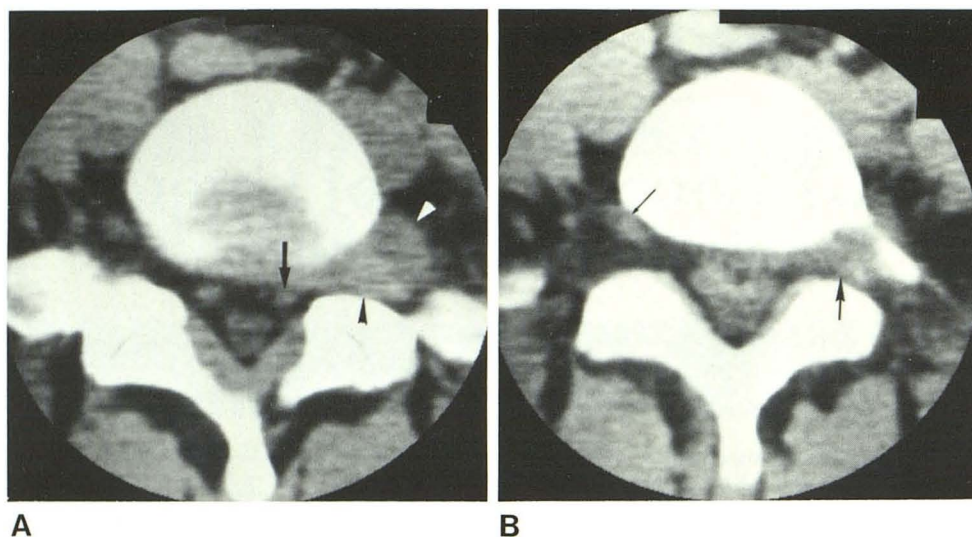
Case 1. Lateral L5–S1 disk herniation. A, CT image through disk. Large soft-tissue mass (*arrowheads*) within left intervertebral foramen and paravertebral tissues. Fat within foramen has been displaced. Left S1 root sheath (*arrow*) contacted by extruded disk material and displaced posteriorly. B, 5 mm cranial. Displacement of fat within left intervertebral foramen by disk material (*large arrow*). Ipsilateral L5 nerve obscured, although contralateral one (*small arrow*) is clearly demonstrated.
